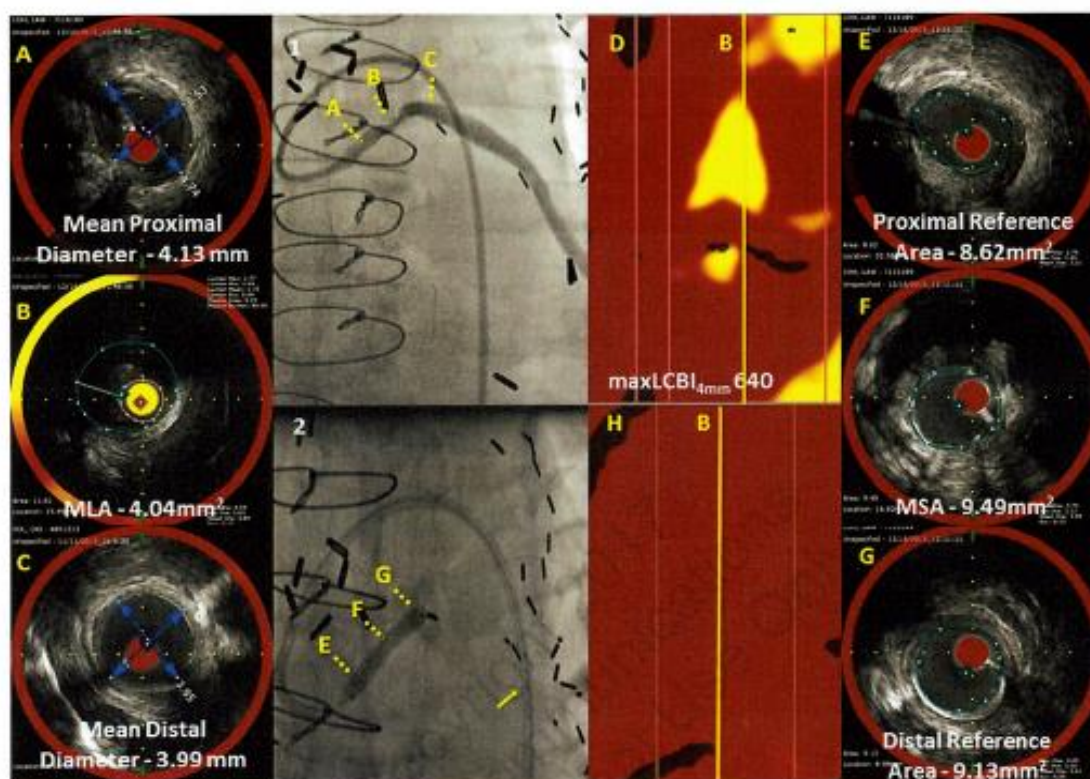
[1] Ultra-low contrast angiography identified a lesion in the proximal saphenous vein graft (SVG) to first obtuse marginal artery [fractional flow reserve 0.74; coronary flow reserve 1.8] in a patient with chronic kidney disease (CKD) stage V. Intravascular ultrasound (IVUS) marked the [A] proximal reference, [B] minimal luminal area, and [C] distal reference. [D] The block chemogram identified a large lipid core with max lipid core burden index (LCBI_{4mm} 640), [2] based on which embolic protection device (EPD; yellow arrow) was deployed followed by stenting with a 3.50 x 20 mm drug-eluting stent (DES). Postdilation was performed with a non-compliant 3.75 x 15 mm balloon at 20 atm to areas of underexpansion identified by IVUS. Following PCI optimization, the [E] proximal reference area was found to be smaller than the [F] minimal stent area and [G] distal reference area confirming optimal stent expansion. [H] The block chemogram showed a significant reduction in the lipid burden (max LCBI_{4mm} 120) and absence of yellow at the site of previous max LCBI consistent with lipid embolization, captured in the EPD [B]. Improved fractional flow reserve (0.91) and coronary flow reserve (3.1) confirmed physiological improvement. (continued)
